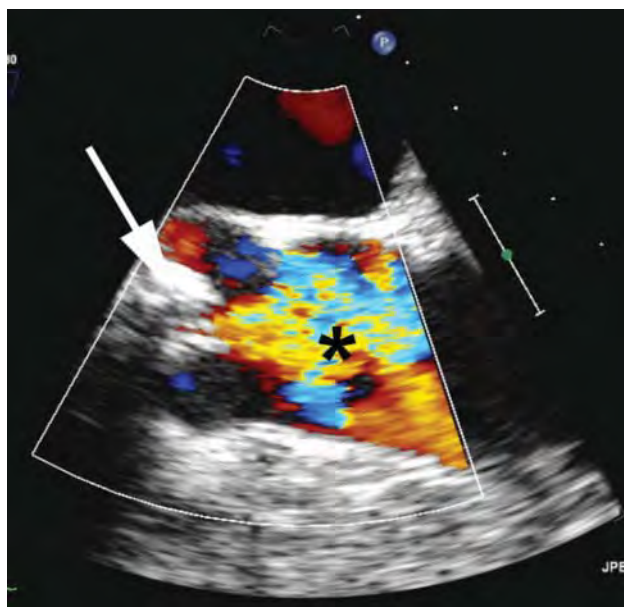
Color Doppler echocardiography parasternal long-axis view showing flow across the stenotic aortic valve (arrow). Color Doppler is turbulent as evident by the pixilation of the color (asterisk).
